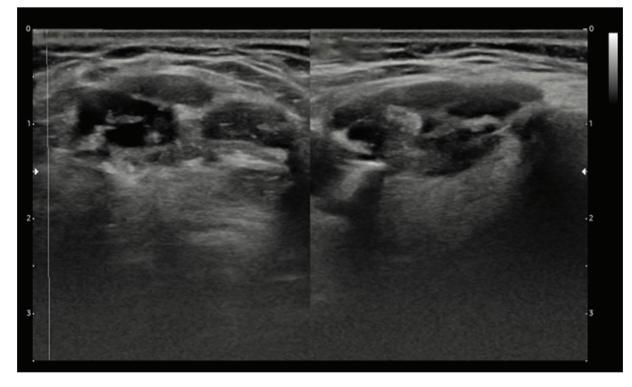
A well-defined complex nodule of 22x15x10 mm is seen in the midline of the neck at the level of the hyoid bone in a 48-year-old female, via ultrasound imaging (Case 2).
